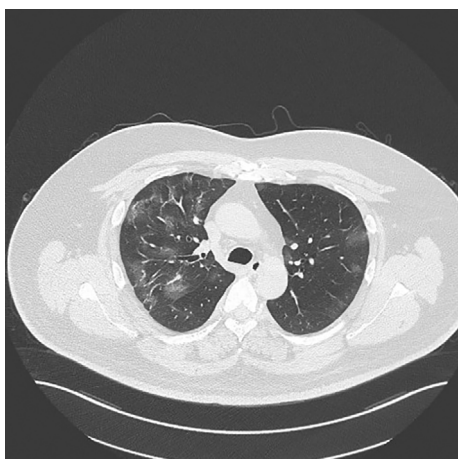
Computed tomography of the chest showing multifocal bilateral ground-glass opacity pulmonary lesions.
